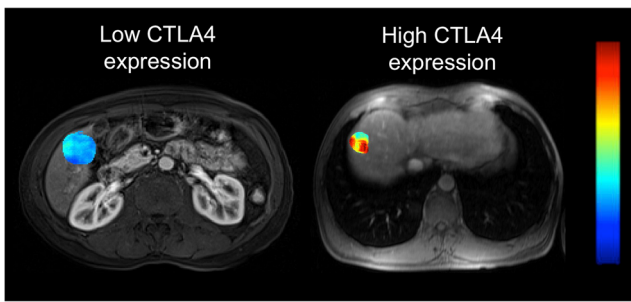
Energy texture maps overlaid on T1-weighted post-contrast image obtained during the late arterial phase image. Left: 59-year-old male HBV patient with a 3.7-cm HCC lesion in right hepatic lobe. Energy texture map overlaid on T1-weighted post-contrast image obtained during the late arterial phase image. Texture feature Energy with 16 bins was 0.025 in the lesion, with corresponding molecular expression of immunotherapy target CTLA4 of 0.44. Right: 51-year-old male HBV patient with a 3.3-cm HCC lesion in right hepatic lobe. Texture feature energy with 16 bins was 0.061 in the lesion, with corresponding molecular expression of immunotherapy target CTLA4 of 0.68. The texture feature maps are coloured according to the scale bar on the right with a range of [0–0.1]
